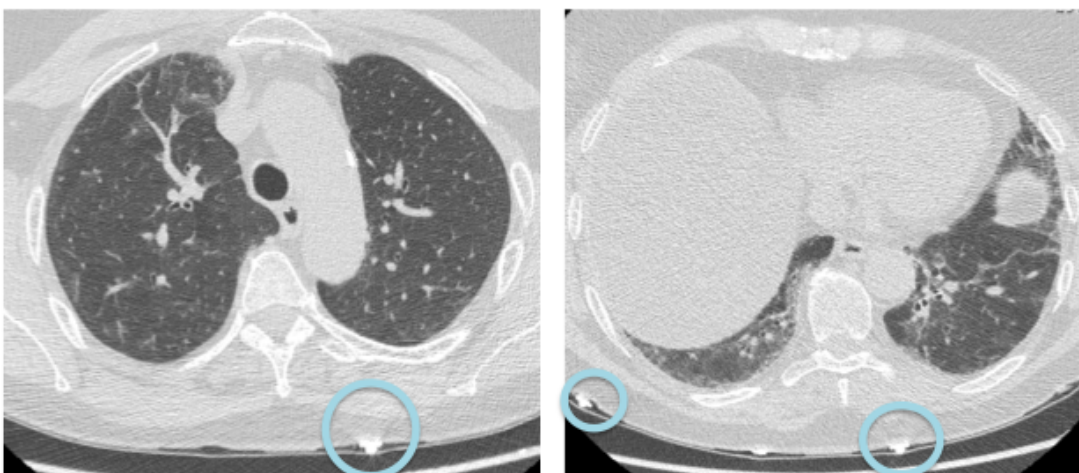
High Resolution Computed Tomography (HRCT) sections showing metallic marks (electrodes) applied to the posterior chest of the patient.
